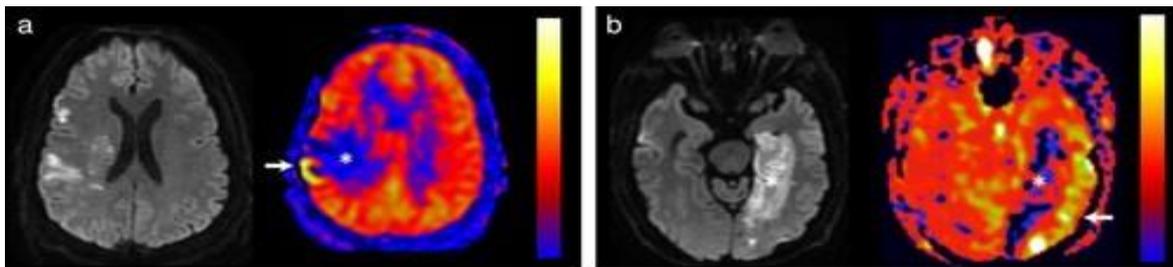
ASL in Acute ischemic infarction. (a) Acute right MCA territory infarct with patchy restricted diffusion. DWI-ASL mismatch with large ischemic penumbra (asterisk) indicating tissue at risk. There is mild overlying arterial transit artifact (ATA) (arrow). (b) Subacute left PCA territory infarct. DWI and ASL abnormalities are nearly matched (asterisk), indicating near-complete infarct with small volume of tissue at risk. Diffuse overlying ATA (arrow) indicates maximal compensatory vasodilation. (17)
